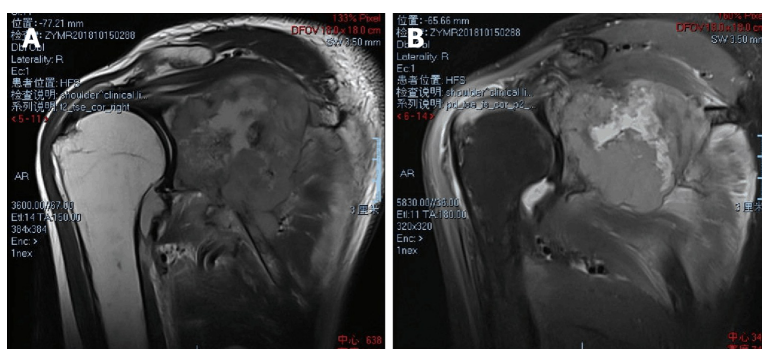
Magnetic resonance imaging A (t2-tse) and B (pd-tse-fs) show an osteolytic destructive lesion in the right scapular bone, invading the surrounding muscles and soft tissues.
